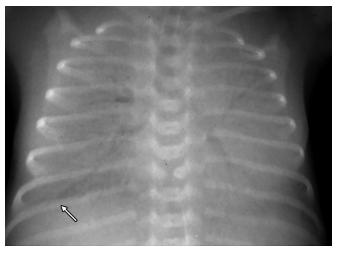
Chest X-ray of an infant with hyaline membrane disease (HMD): low lung volumes, homogeneous opacities, ground glass appearance. Air bronchograms can be seen (white arrow)
